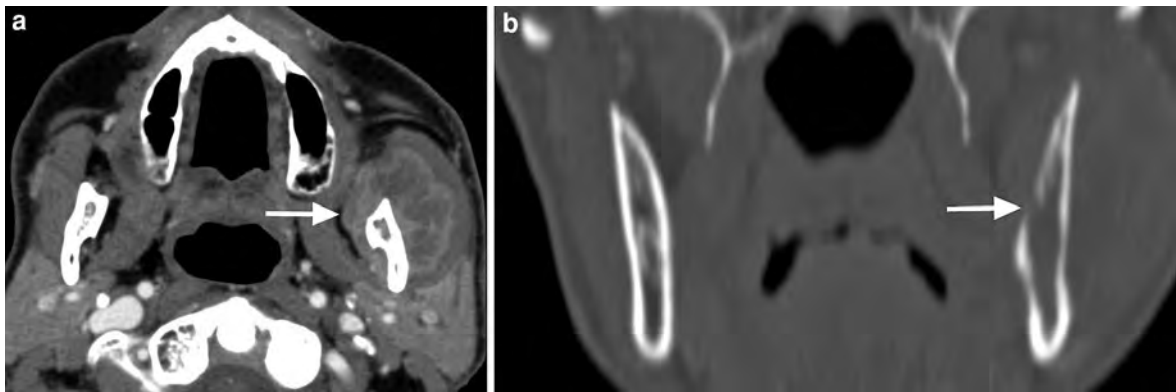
Malignant intrinsic lesion of the left masticator space in a 67-year-old female with trismus and dysaesthesia of the left V3 territory with biopsy-proven osteosarcoma. a Axial contrast-enhanced CT image shows a soft tissue mass in the masticator space surrounding the left mandibular ramus
